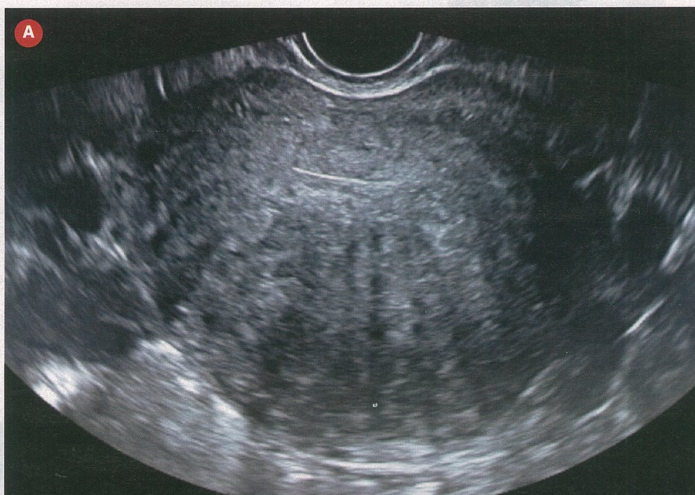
Transvaginal ultrasound of adenomyosis.
